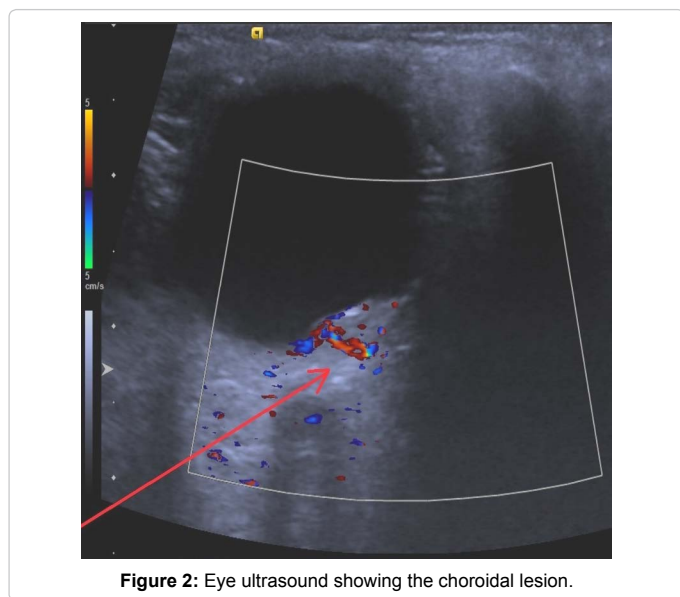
Eye ultrasound showing the choroidal lesion.
